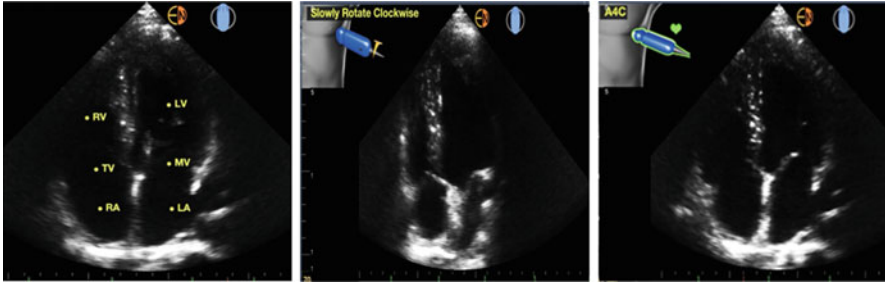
Apical 4 chamber views of the heart with artificial intelligence assistance. Left panel: anatomical structures labeled—left ventricle (LV), mitral valve (MV), left atrium (LA), right ventricle (RV), tricuspid valve (TV), and right atrium (RA). Middle panel: instructions to rotate the probe clockwise for a better image. Right panel: the result of rotating the probe clockwise
